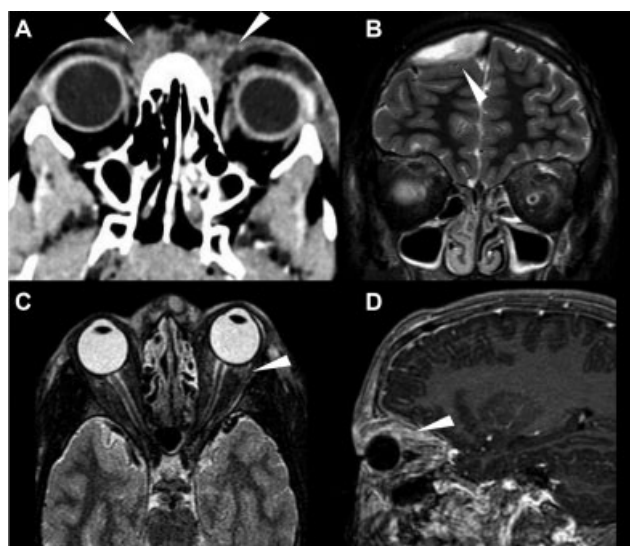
Orbital cellulitis. A – Computed tomography without contrast: Thickening and heterogeneity of bilateral periorbital soft tissue with extension of the nasal and malar region (arrows). B, C and D – T2WI and T1 postcontrast show preseptal and postseptal compartments. The inflammatory process involves the orbital musculature (arrows). Extradrainary empyema is also noted in the right frontal convexity (arrow in b).
